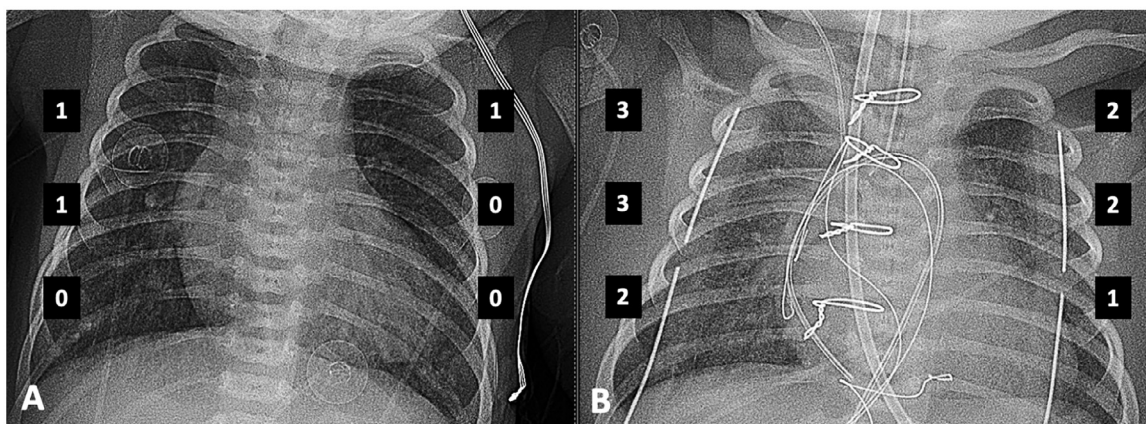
Chest radiographs of a dTGA/IVS patient demonstrate the assigned score of each lung zone. (A) Preoperative Brixia score (1+1+0+1+0+0) = 3. (B) Postoperative Brixia score (3+3+2+2+2+1) = 13.
